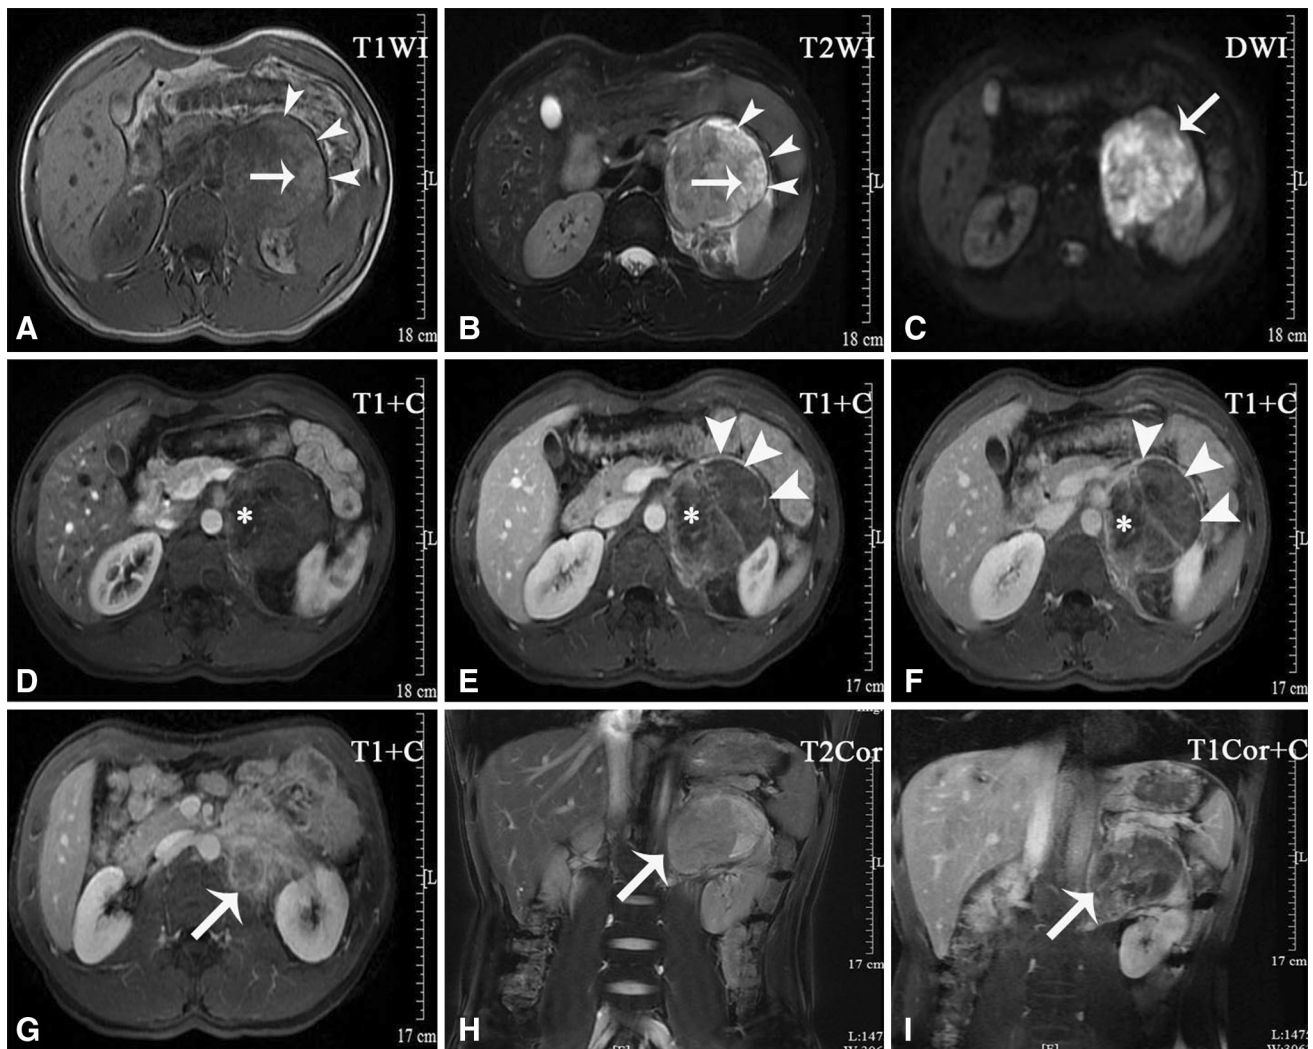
MRI findings of a 36-year-old man (case 7) with an adrenal PNET in the region of the left adrenal gland (a–i). The signal intensity of the tumor was heterogeneous and slightly hypointense and hyperintense on the T1- and T2-weighted images, respectively (a, b). A patchy abnormal signal area within the tumor with a hyperintense signal on both T1- and T2-weighted images was observed, indicating hemorrhage (a, b arrows). Diffusion-weighted
